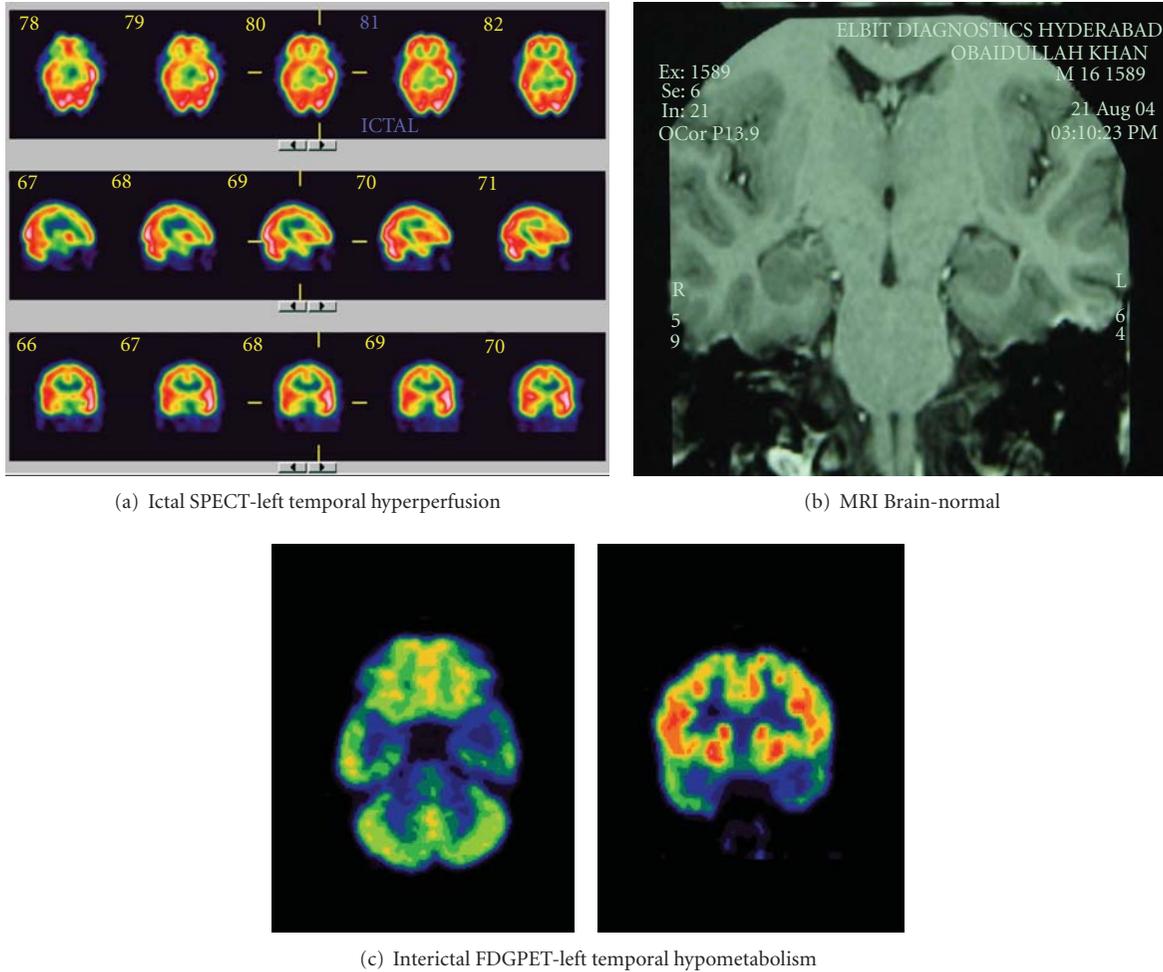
Ictal SPECT and FDGPET in a patient with refractory temporal lobe epilepsy and normal MRI showing lateralization to left. The patient underwent left temporal lobectomy with amygdalohippocampectomy and is seizure free for more than 3 years.
